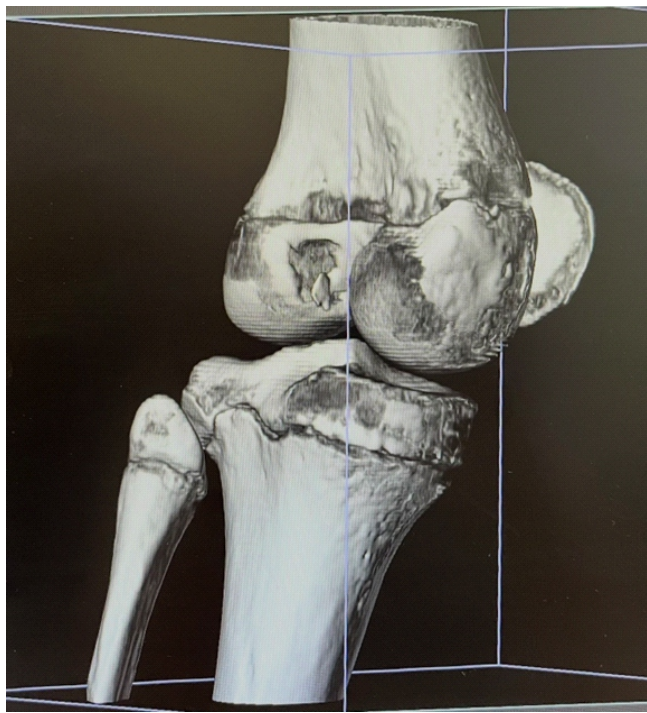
Six-week post-operative 3D computed tomography reconstruction demonstrating maintained fragment position.
